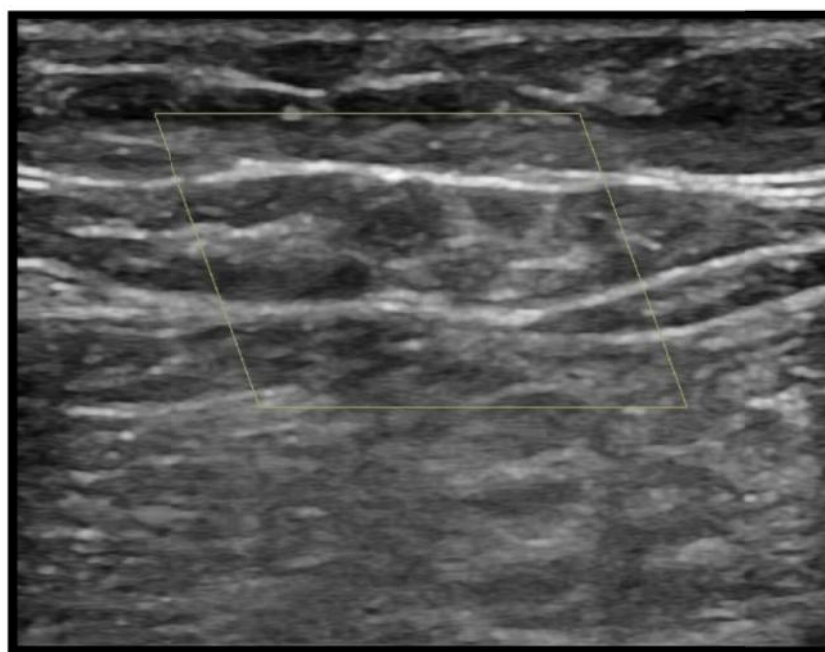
Post EVLT: Colour doppler image of thrombosed GSV (longitudinal view)
